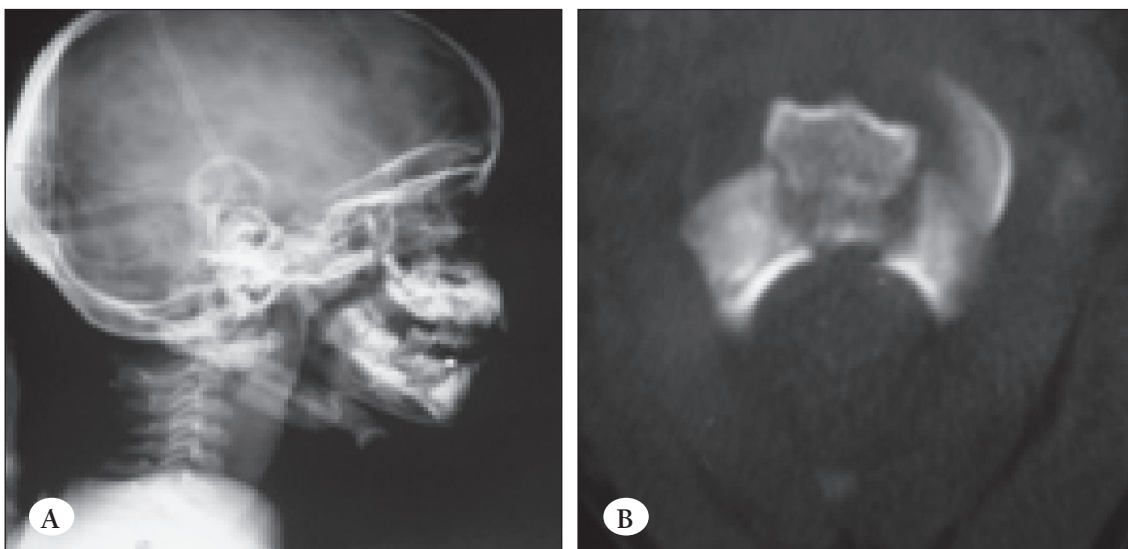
Cervical X-ray showing anterior displacement and odontoid fracture (Type IC synchondrotic fracture according to Hosalkar) (1A). Cervical tomography showing anterior displacement and odontoid fracture (Type IC synchondrotic fracture according to Hosalkar) (1B).
